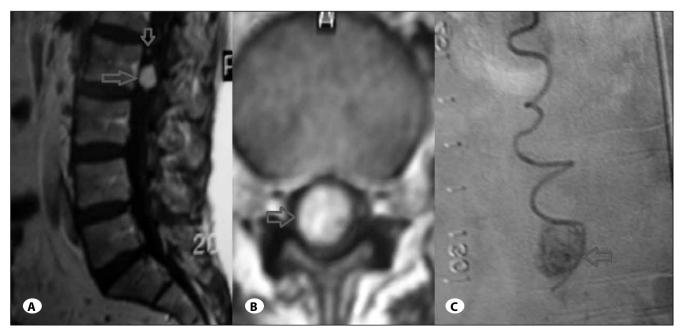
A) Sagittal T1-weighted MRI of the lumbar spine with contrast showing a 1.5 cm diameter intradural tumor at L2 level, which was brilliantly enhancing after gadolinium infusion (small arrow is showing arterial feeding from superior pole of the mass, large arrow is showing the hypervascular lesion). B) Axial T1-weighted MRI of the lumbar spine with contrast showing an intradural lesion (arrow). C) Selective spinal angiography showing arterial supply (anterior spinal artery) and high vascularity of the tumor (arrow).
